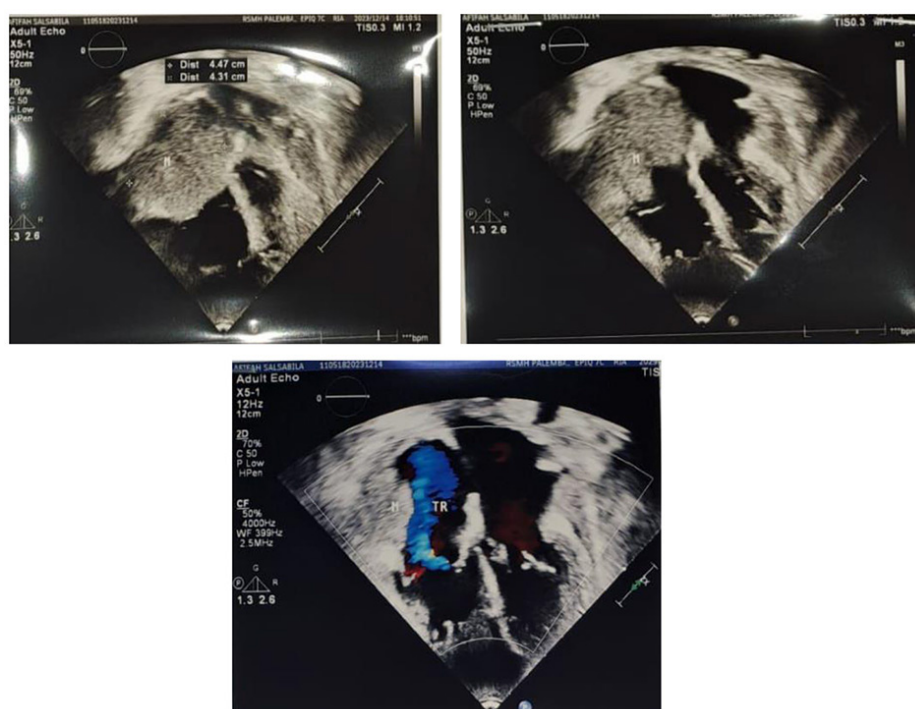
Echocardiography of Case 2
